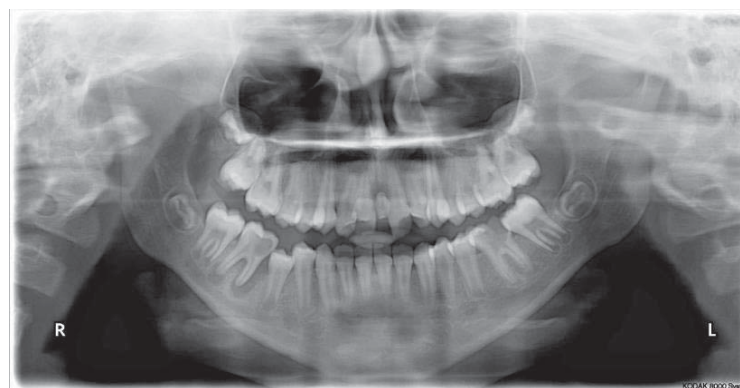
Initial orthopantomography of patient S. A.
